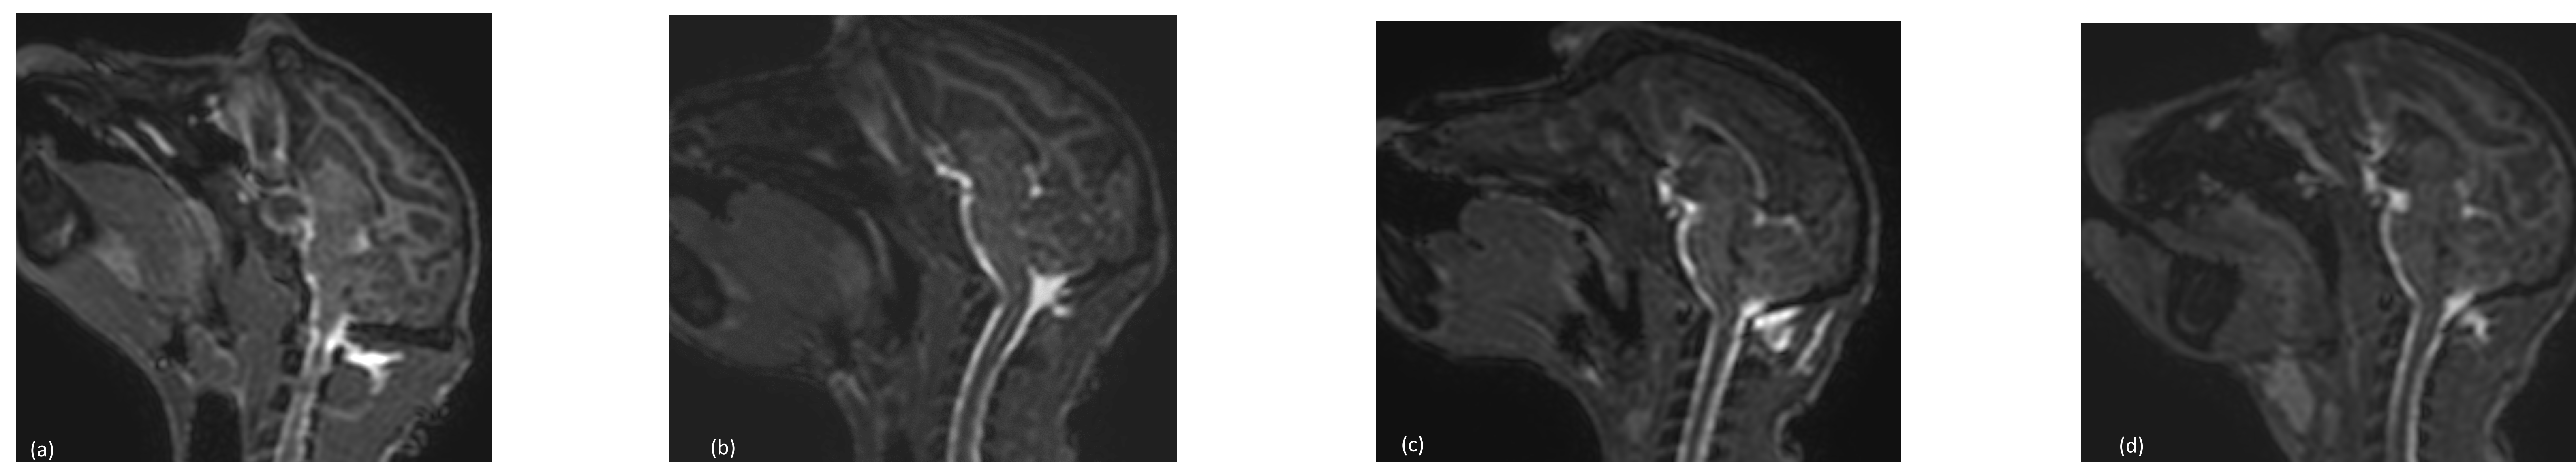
Screenshots of representative T1-weighted MR images. (a) 22-G Q, (b) 25-G Q, (c) 22-G GM, and (d) 24-G GM.
